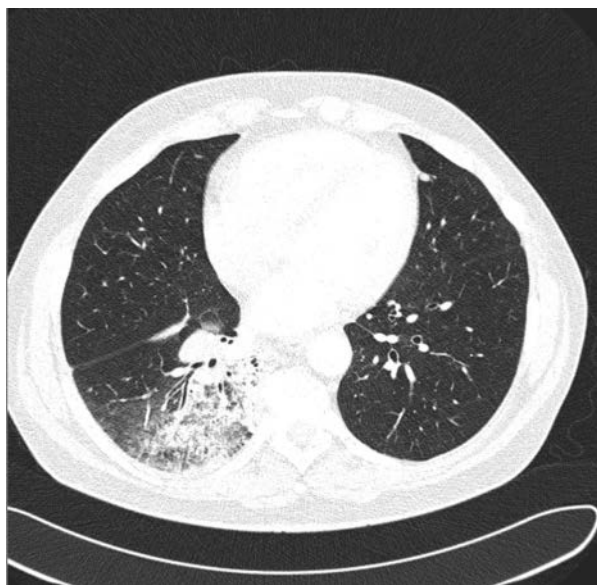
Lung HRCT. Parenchymal consolidations with ground glass opacities in right inferior lobe with a sign of air bronchogram
